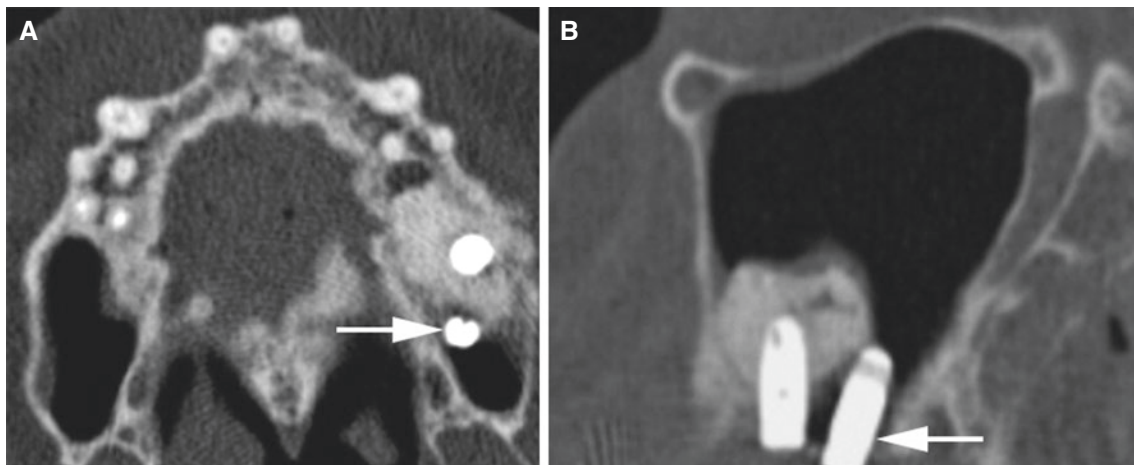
Postoperative imaging, maxilla; 63-year-old male with sinus lift and bone graft. (A) Axial and (B) sagittal CBCT images show one implant correctly inserted in graft, whereas the other (*arrow*) is not
